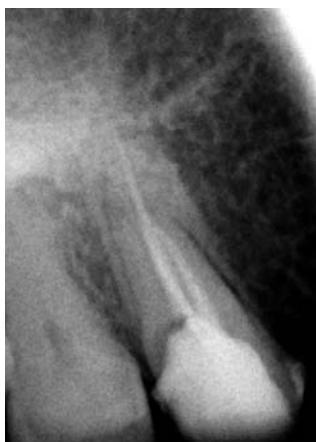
Straight angled radiograph suggests a missed distal canal
